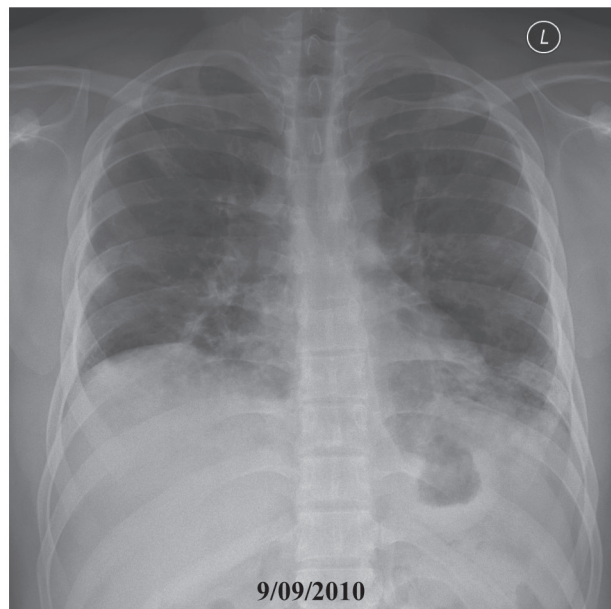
After Treatment; chest x-ray shows decrease pulmonary infiltration.
